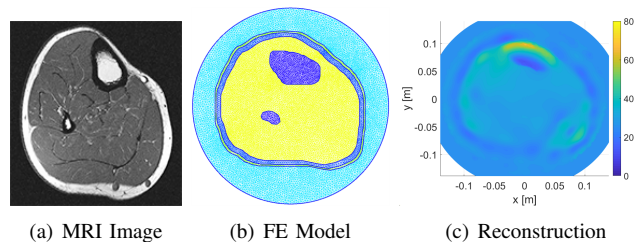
The forward model and inversion algorithm reconstruction: (a) MRI image [6], (b) 2D FE model, (c) relative permittivity reconstruction
